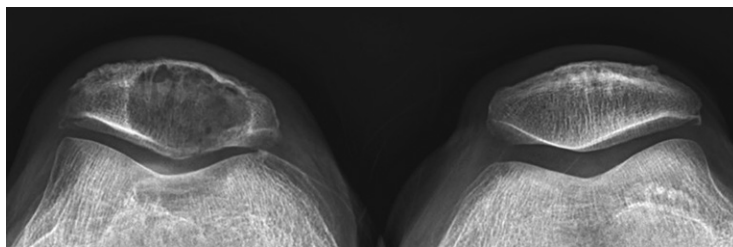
Plasmacytoma of the patella in a 67-year-old man with a history of facial plasmacytoma who presented with knee pain and was found to have a lytic lesion of the patella. Axial radiograph of both knees shows a well-defined lytic lesion in the central portion of the right patella, associated with erosion of the subchondral bone at the medial facet. Biopsy demonstrated plasmacytoma.
